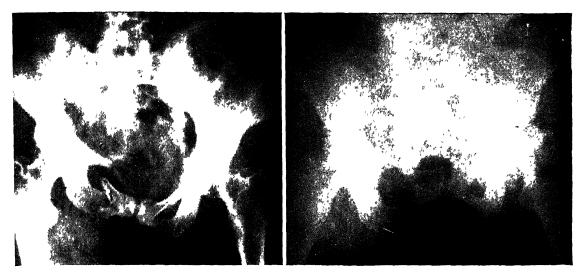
Lett, Malgaigne type of fracture showing hemisubluxation of the pelvis. Right, Roentgenogram of same patient taken after reduction of the fracture by means of traction in a Hodgen splint. (Leydig and Key. Surg., Gynec & Obst.)
